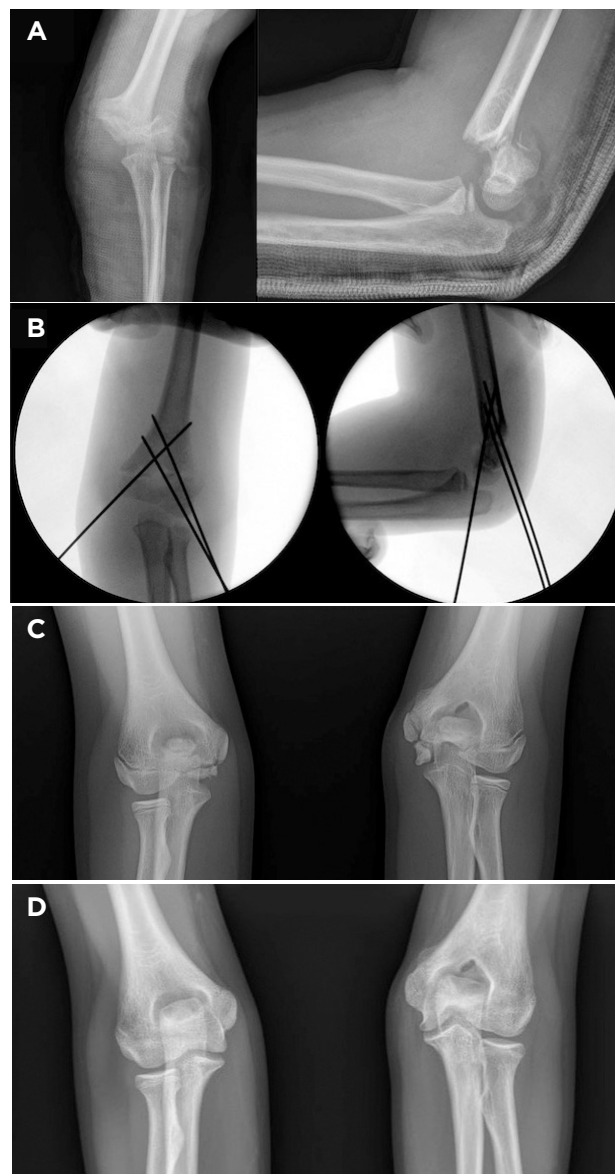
A) Radiographs of a left Gartland 3 extension type supracondylar humerus fracture (patient age 8); B) Fluoroscopic images of treatment with closed reduction and percutaneous pinning; C) Radiograph of bilateral elbows demonstrating development of contour abnormality of the left distal humerus secondary to lateral trochlear ossification center involvement 2.5 years after injury; D) Radiograph of bilateral elbows, four years after injury with resultant central epiphyseal deficiency and characteristic "fishtail deformity."
